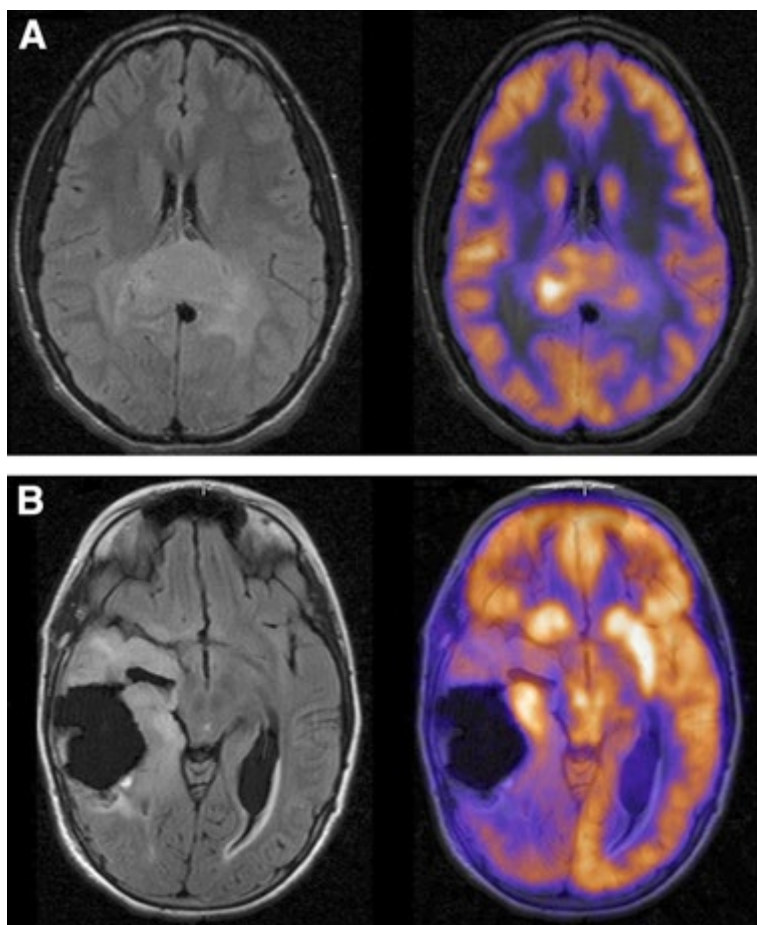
FIGURE (Adapted From): (A) Flair-MRI (left) and fused PET-MRI (right) in an 18-y-old boy with newly diagnosed Glioblastoma Multiforme showing uptake of ^{18}F -fluorodeoxyglucose (^{18}F -FDG) in the tumor (red arrows). (B) Flair-MRI (left) and fused PET-MRI (right) in an 11-y-old girl with recurrent Glioblastoma Multiforme showing uptake of ^{18}F -FDG in the tumor (yellow arrows).¹
